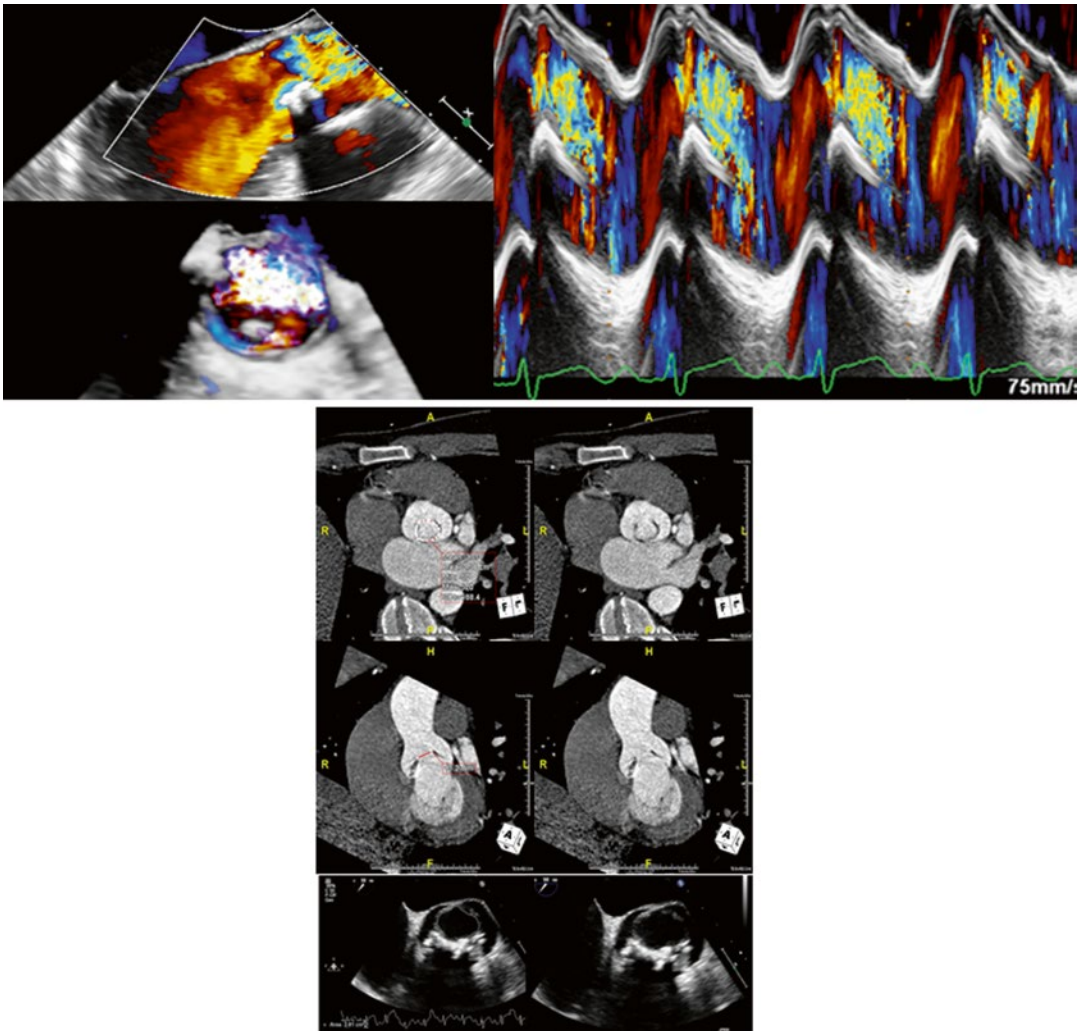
Case 4: Pressure recovery: insignificant pressure recovery and high transaortic valve flow in a patient with a bicuspid aortic valve. (Doppler- and invasive- reverse area/gradient mismatch). 24 year-old male with a bicuspid AV and an eccentric jet, moderate to severe aortic regurgitation, and mildly dilated aortic root (3.6 cm) all leading to marked increase and concordance (due to no significant P_{rec}) of both Doppler and catheter derived ΔP , despite non severe AS by
